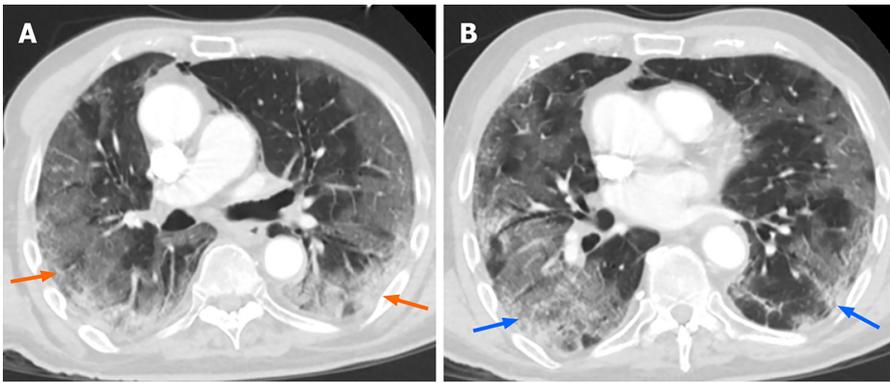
Postcontrast axial computed tomography chest in lung windows (A and B) show bilateral basal and peripheral consolidative opacities with patchy ground glass opacities in crazy-paving pattern in coronavirus disease 2019 infected 63 year old patient (orange and blue arrows).
